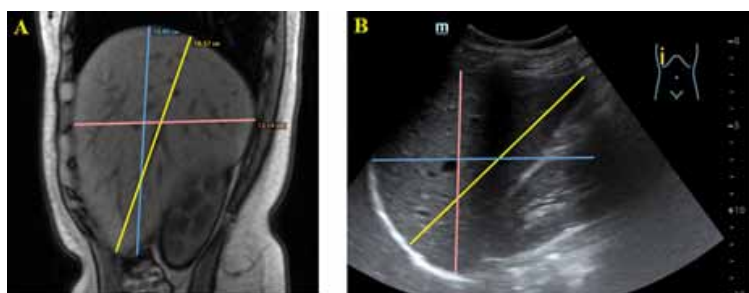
Measurements of the right liver lobe in volunteer K., 23 years old: A — MRI, B — US (transducer orientated longitudinally in the VII-X intercostal spaces in the anterior axillary line). Yellow color indicates the oblique maximum craniocaudal diameter, blue — the craniocaudal diameter, pink — the anteroposterior diameter
